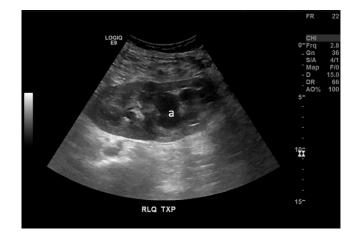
Renal ultrasound showing (a) hydronephrosis of the lower pole of the transplanted kidney.
